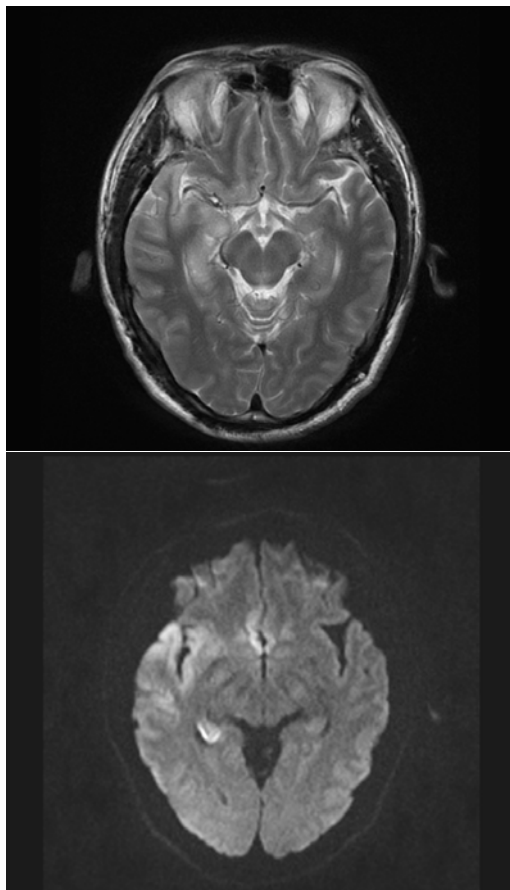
Axial T2-weighted image and diffusion-weighted image demonstrating cortical edema affecting the right frontal and temporal lobes
